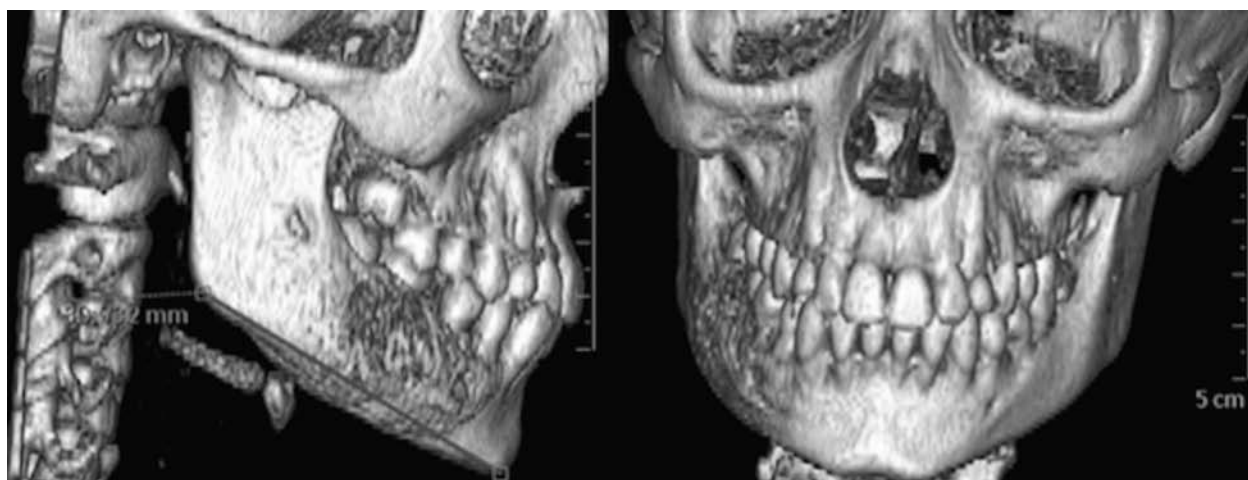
Preoperative CT scan showing an Ewing sarcoma located in the right body of the mandible, as an ill-defined lesion with osteolytic changes and erosion of the buccal cortex.
